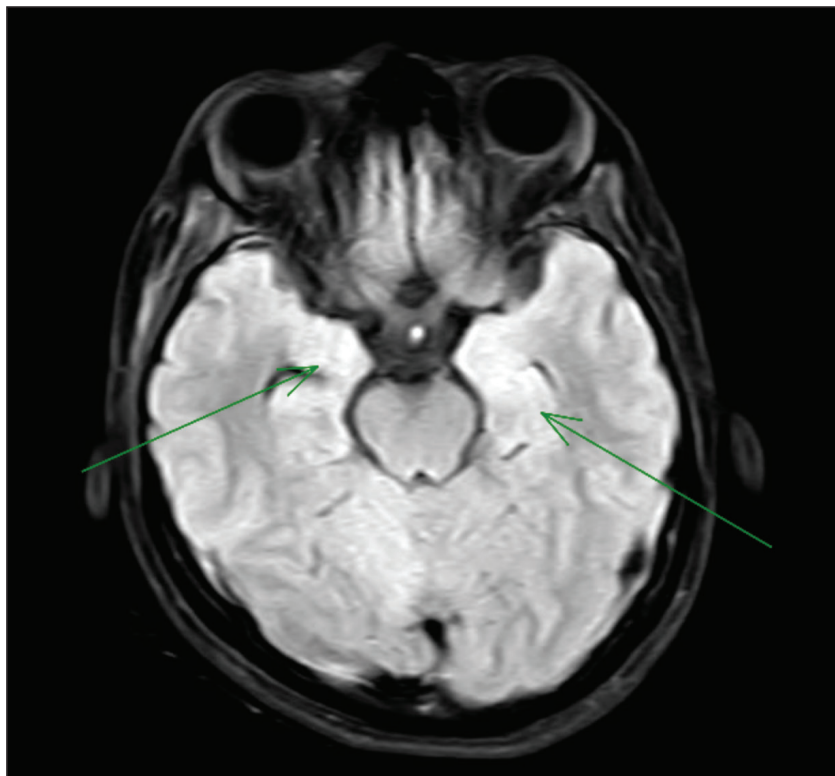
Brain MRI shows hyperintense of bilateral temporal lobe on FLAIR.
